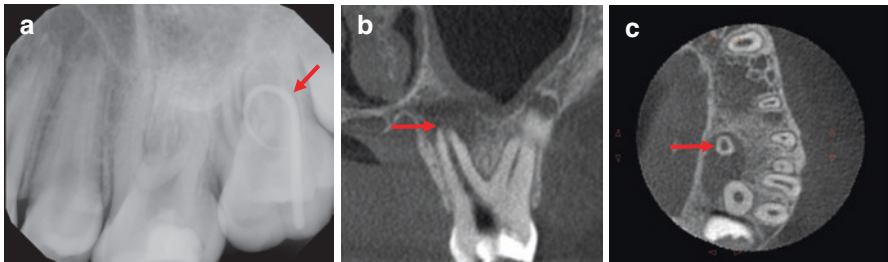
Palatal sinus tract. A palatal sinus tract adjacent to tooth #15 was traced with gutta-percha (arrow) and suggested a primary endo lesion associated with recently erupted #15 (a). Teeth #13, 14, and 15 all responded positively to cold testing. A limited field of view CBCT of the area (without gutta-percha in the sinus tract) demonstrated a distinct periapical lesion associated with the P root of #14 (b and c; arrows pointing to the P root apex, in coronal and axial views, respectively). On endodontic access of #14, some vital tissue was found in the MB and DB roots (explaining the positive response to cold), and the P root was completely necrotic. The sinus tract resolved after initial canal space debridement and placement of calcium hydroxide paste as an interim intra-appointment medication in tooth #14
